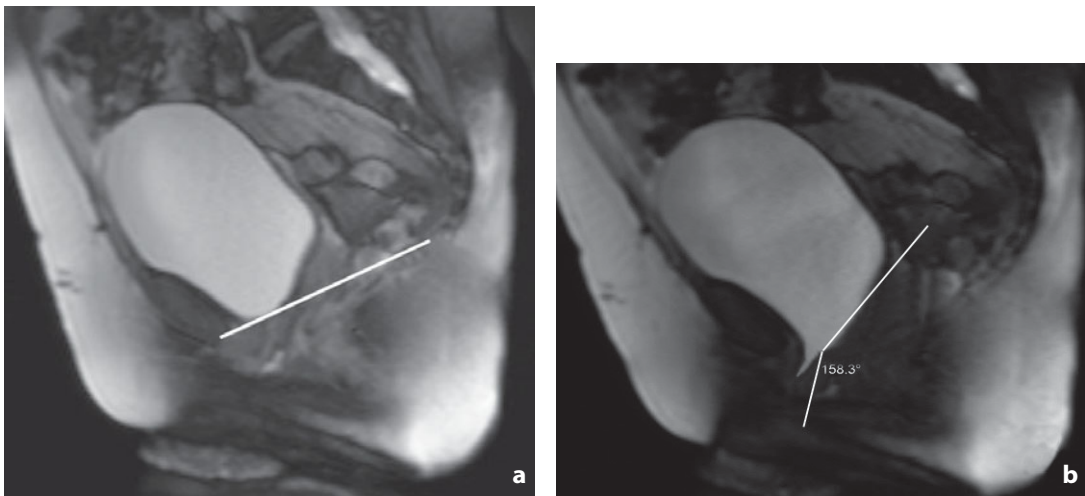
Dynamic magnetic resonance of the pelvis. Median sagittal scan with T2-weighted “single-shot” true FISP sequences. a At rest, the position of the pelvic organs is normal. b During straining a nonsignificant descent of the bladder base can be seen, but with involuntary loss of urine and increase in the posterior vesicourethral angle
